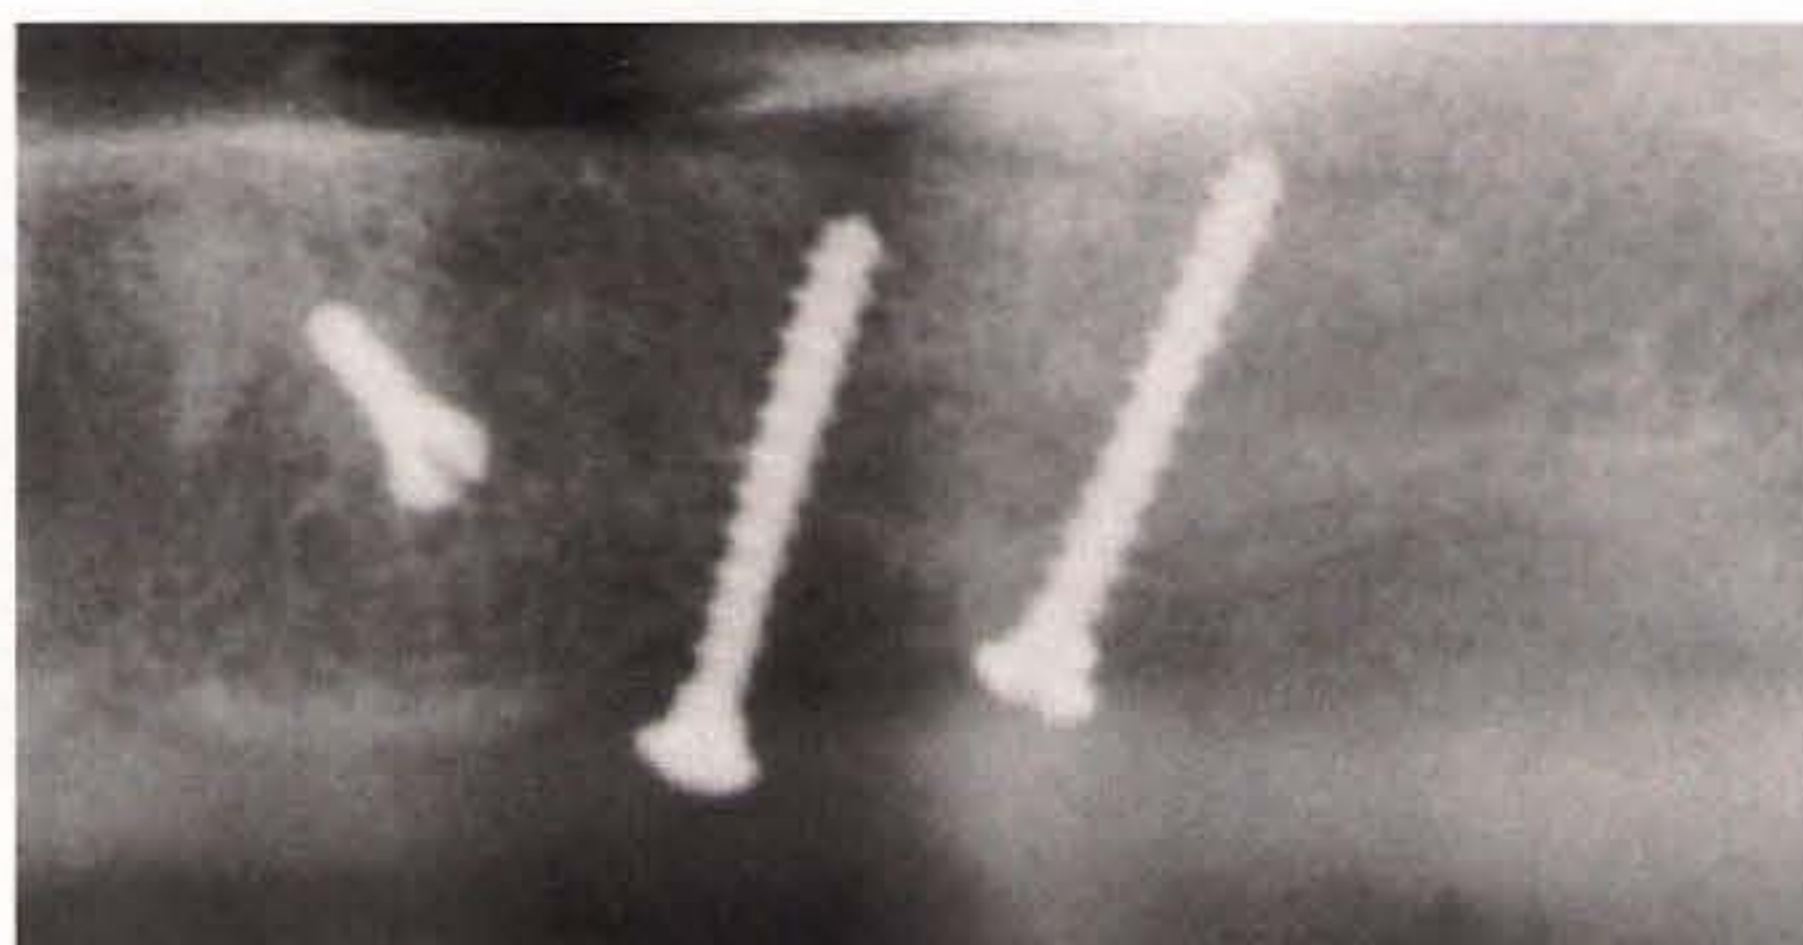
Radiograph revealing optimal integration of the grafted bone.
